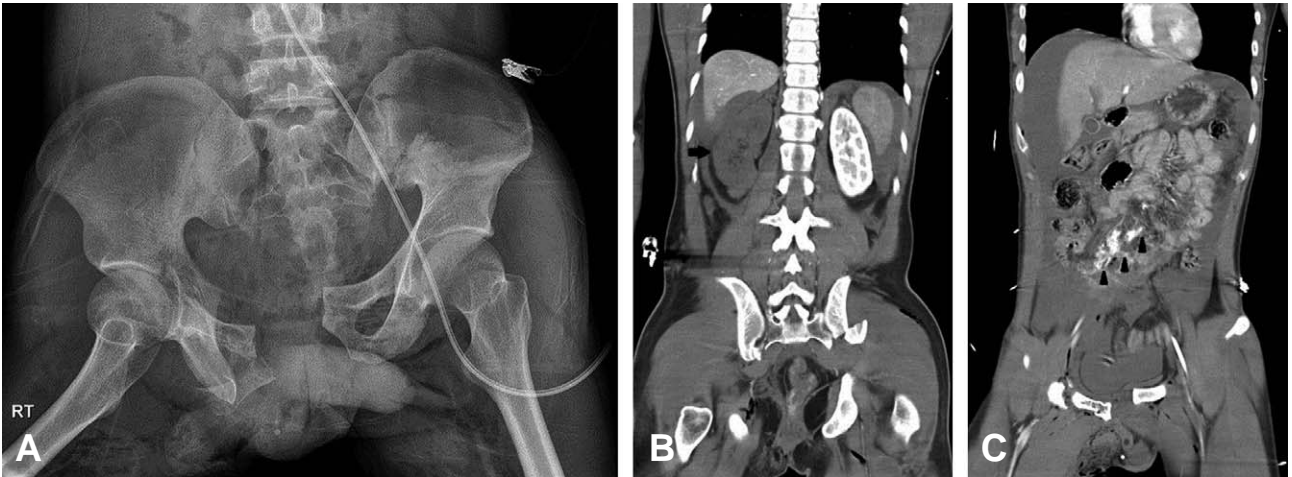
Pelvic AP scan showing anteroposterior compression type 3 pelvic fracture (A). Coronal view abdominal CT scan showing complete infarction of the right kidney (B) and mesenteric bleeding (C).
